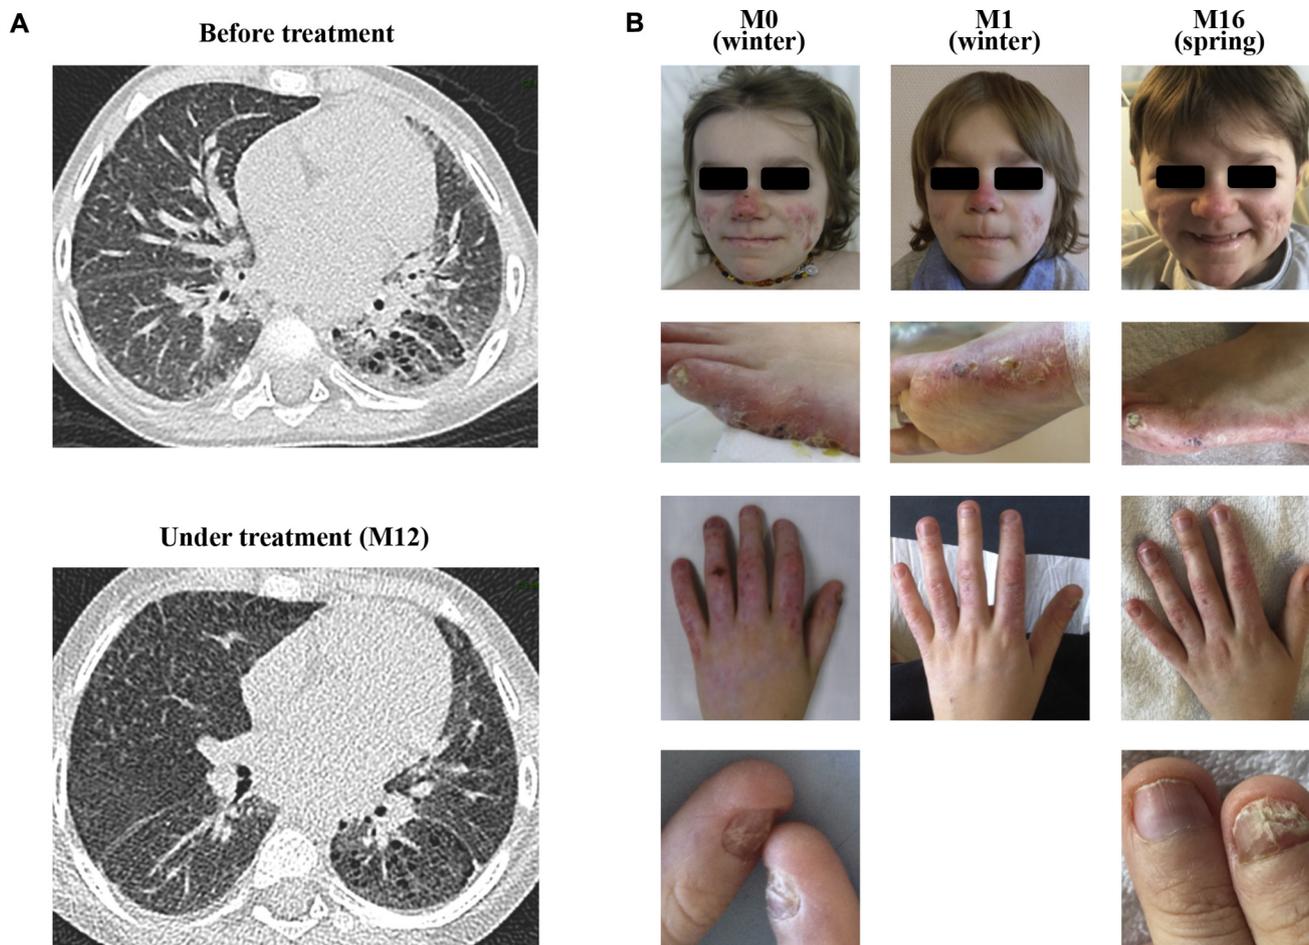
Clinical response of patients with *TMEM173* mutations to treatment with ruxolitinib. A, High-resolution chest computed tomography of P1 demonstrating improvement in ground-glass lesions and stabilization of fibrosis after 12 months (M12) of treatment with ruxolitinib. B, Cutaneous involvement observed in P2 before (M0) and after 1 (M1) and 16 (M16) months of treatment with ruxolitinib. Healing of the cheek and nose ulcerations was noticed within a month of the initiation of ruxolitinib. Ulcerations of the digits, erythematous scaling plaques of the feet, and nail dystrophy improved after 16 months of treatment. These improvements were not related to season (where such lesions are exacerbated by cold and thus are more prominent in the winter and spring months).
